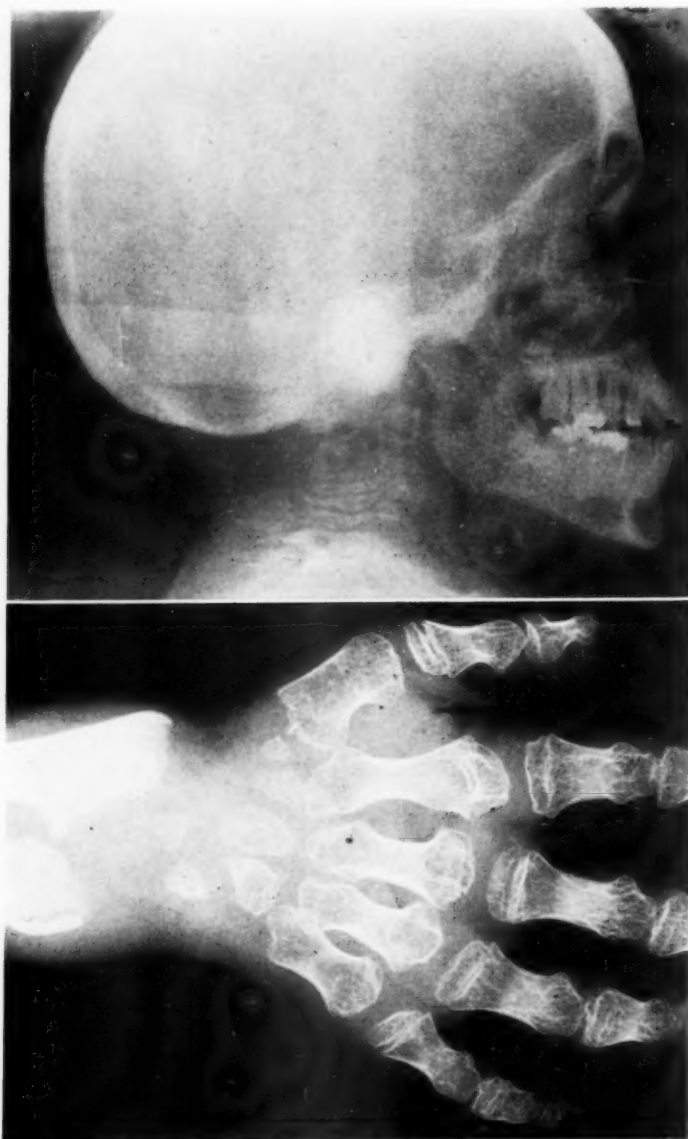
Cranial and postcranial development in Morquio's syndrome (F. D.). *A*, Vertebral compression and near-normal facial and occlusal relationships. *B*, Carpal x-ray picture of F. D., showing spool-shaped, shortened digits, irregular carpal bones, missing epiphyses, and irregular thickened long bones.
